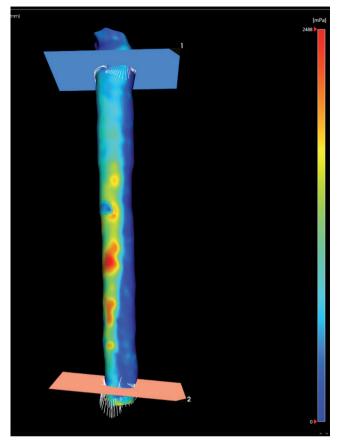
4D MRI image of initial experiment at a HR of 80 bpm. A map of WSS based on 4D MR images (blue = low WSS, red = high WSS).
